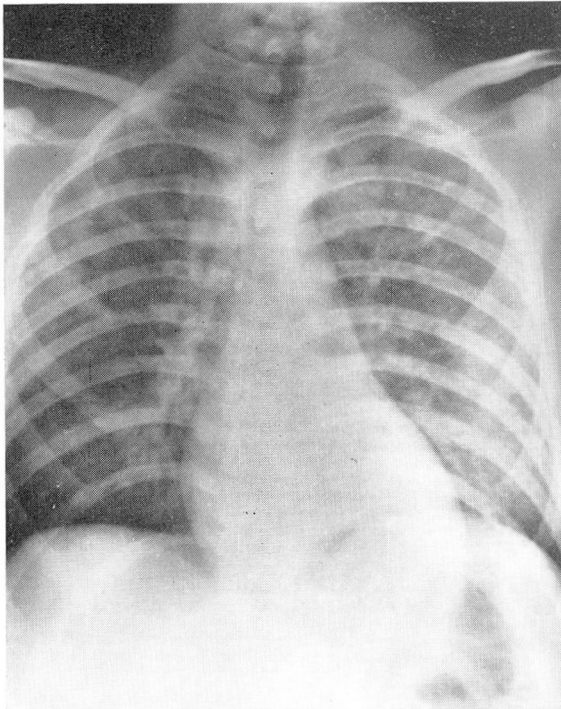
Admission roentgenogram of the chest showing acute pulmonary congestion secondary to massive aortic regurgitation.
